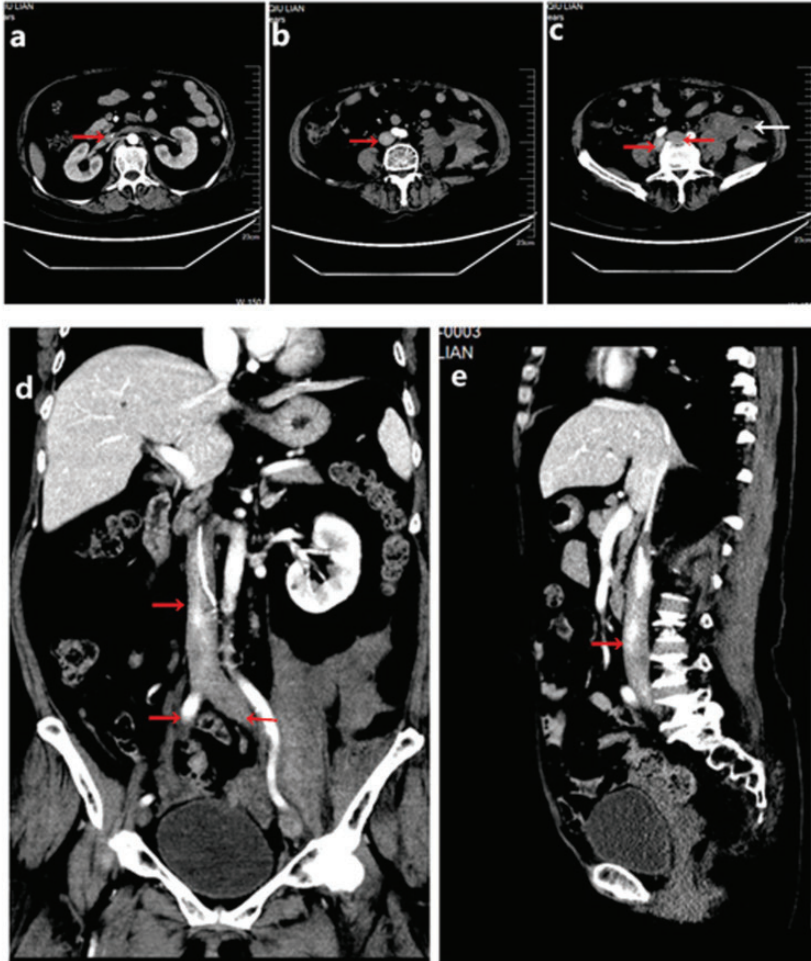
Enhanced computed tomography shows thrombotic embolism in the inferior vena cava (a, b, d, e) and bilateral iliac veins (c) (red arrows). A lower abdominal hematoma around the left iliopsoas muscle was detected (c) (white arrow).
